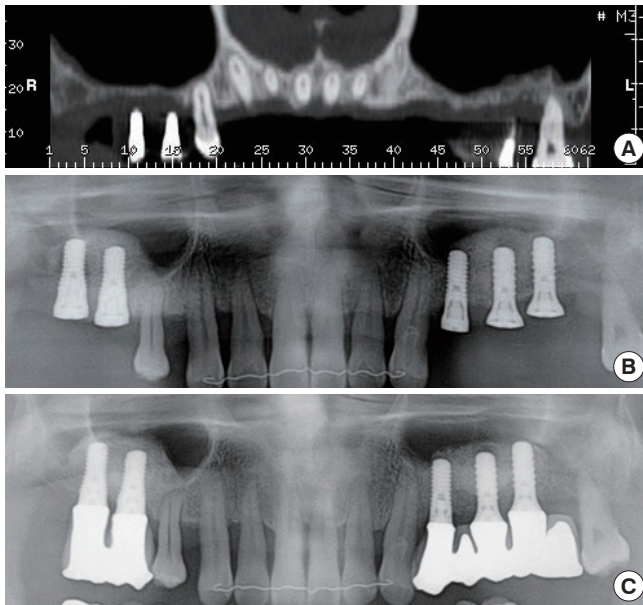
(A) Following extraction of the maxillary premolars and molars due to generalized aggressive periodontitis, a thin alveolar ridge remained. (B) Simultaneous implant placement with sinus floor elevation using a hybrid technique. (C) Radiograph 25 months after surgery.
